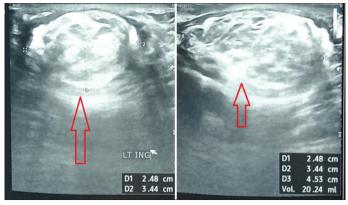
Ultrasonography showing oval-shaped inhomogeneous hyperechoic lesion of size 24×34×45, volume 20cc
